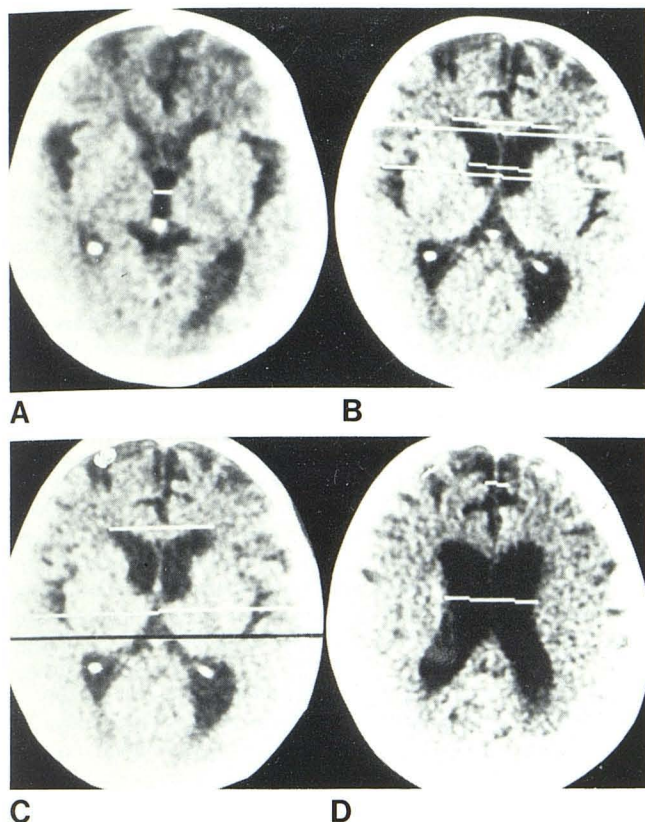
CT criteria used for the study of cerebral atrophy. A, Maximum width of third ventricle. B, Measurements used for determination of bifrontal and bicaudate indices. C, Measurements used for determination of Evans and cella media indices (maximum inner and outer skull widths). D, Measurement of maximum width of hemispheric cortical sulci (frontal lobe excepted), frontal hemispheric cortical sulci, anterior interhemispheric fissure, and combined both cellae mediae.
